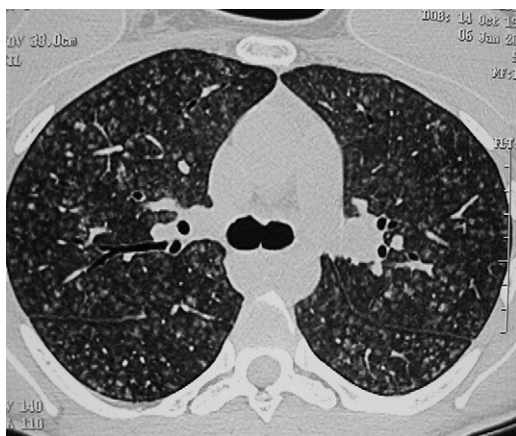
HRCT of a patient with acute hypersensitivity pneumonitis.
